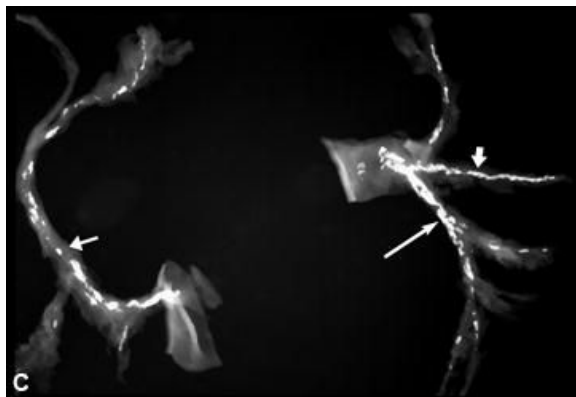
Post-mortem X-rays of 3 hearts before injection of barium gelatin mass (A, B, D) and the dissected coronaries of one heart not injected (C). A, 42-year-old white male who died of cardiogenic shock shows extensive, confluent calcification of the LAD coronary artery (long arrows) and focal discrete calcium deposits of the RCA (short arrows). B, 54-year-old white male who died of SCD outside the hospital. Extensive calcification of all three coronary arteries, particularly the RCA (white arrows), with diffuse confluent calcification. Note the circumferential calcification of the CIRC (black arrow). C, Coronary arteries of a 62-year-old white male who died SCD outside the hospital. The RCA (short thin arrow) shows focal calcification extending into the posterior descending artery. Extensive, confluent calcification is seen in the LAD coronary artery (long arrow), and the intemedius branch (fat arrow). D, 93-year-old white female who died as a result of cardiogenic shock secondary to a large anterior myocardial infarction. Relatively minimal calcification is present in the RCA (short white arrow), the LAD coronary artery (long black arrows), and CIRC (short black arrow) in this elderly patient.
